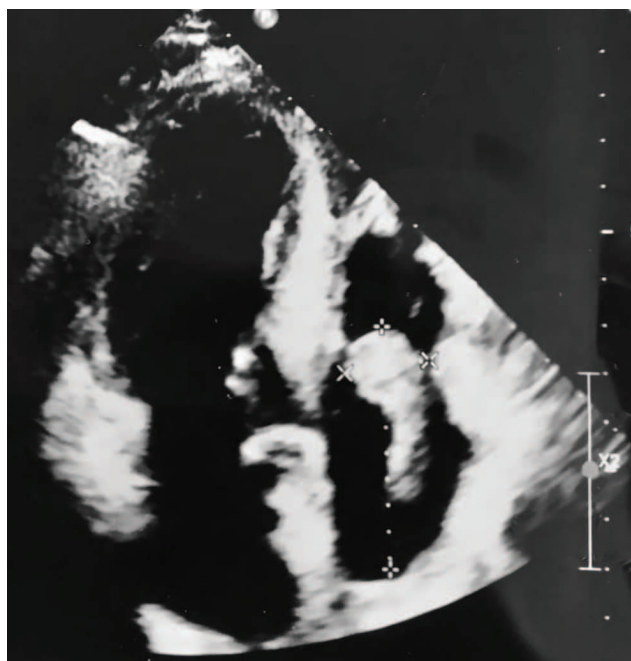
Echocardiography of the patient. Vegetation on the tricuspid valve, clot in the right atrium (described in the text)
